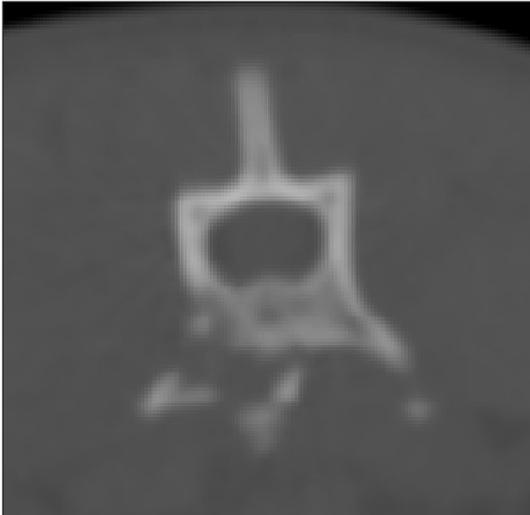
Transverse CT image of the second lumbar vertebra with a comminuted fracture of the ventral aspects of the vertebral body
